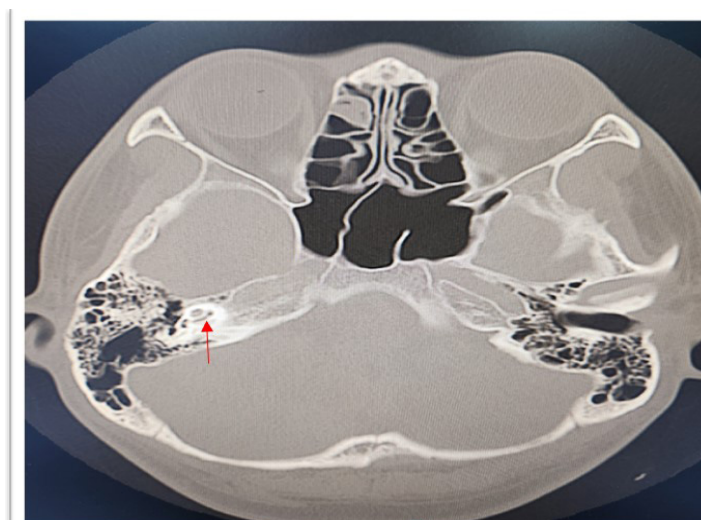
High-resolution Computed Tomography (HRCT) of the temporal bone showed hyperdense basal turn of the right cochlea (arrow)
